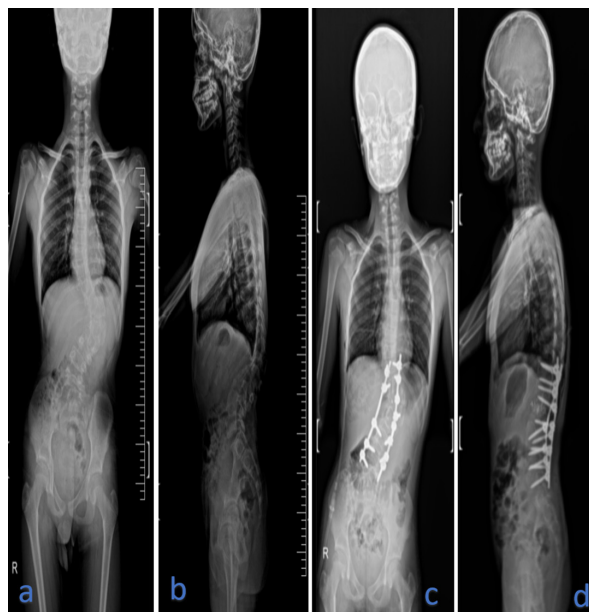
Imaging of a thoracolumbar kyphoscoliosis patient with postoperative pseudomeningocele: preoperative whole spine AP (a) and lateral (b) radiographs, and postoperative whole spine AP (c) and lateral (d) radiographs showing deformity correction.
